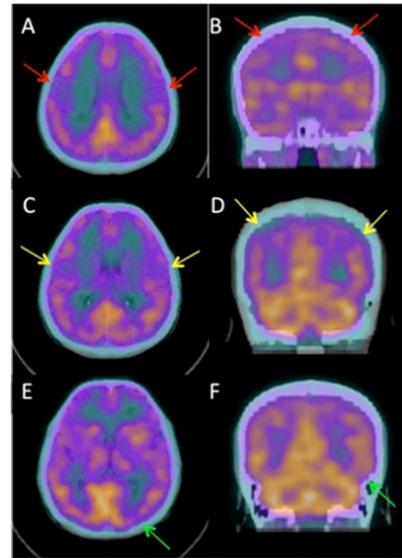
Brain perfusion SPET/CT of patient 1, axial (A-E) and coronal (B-F) slices. Mild to moderate hypoperfusion is detectable in: parietal cortex bilaterally especially in the right upper gyrus (A, B), bilateral temporal cortex (C, D) and the left occipital cortex (E, F), with the qualitative analysis.
